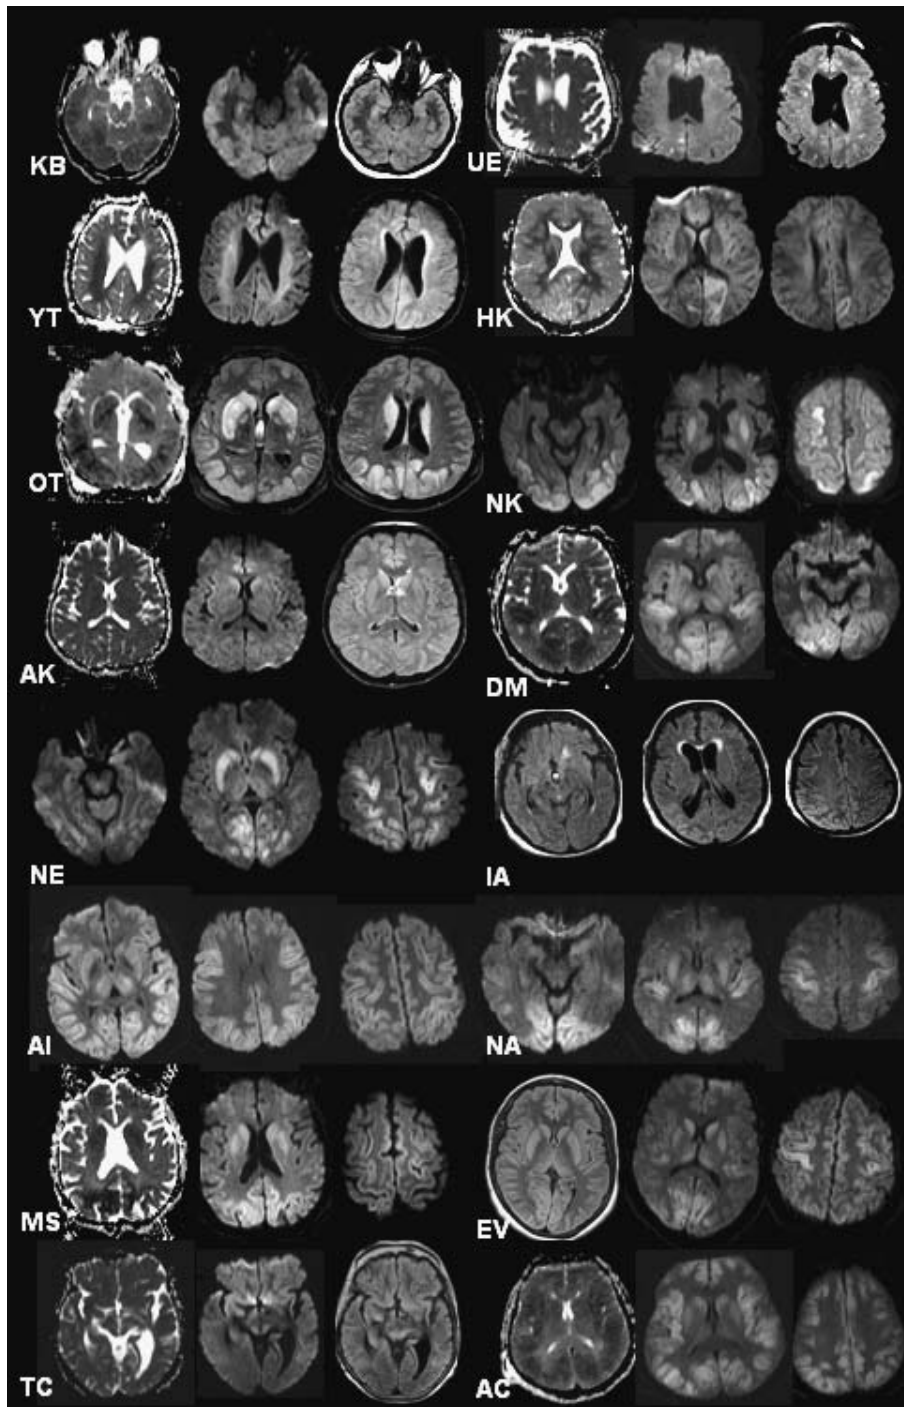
MRI injury patterns in PRE patients who showed a poor prognosis.
